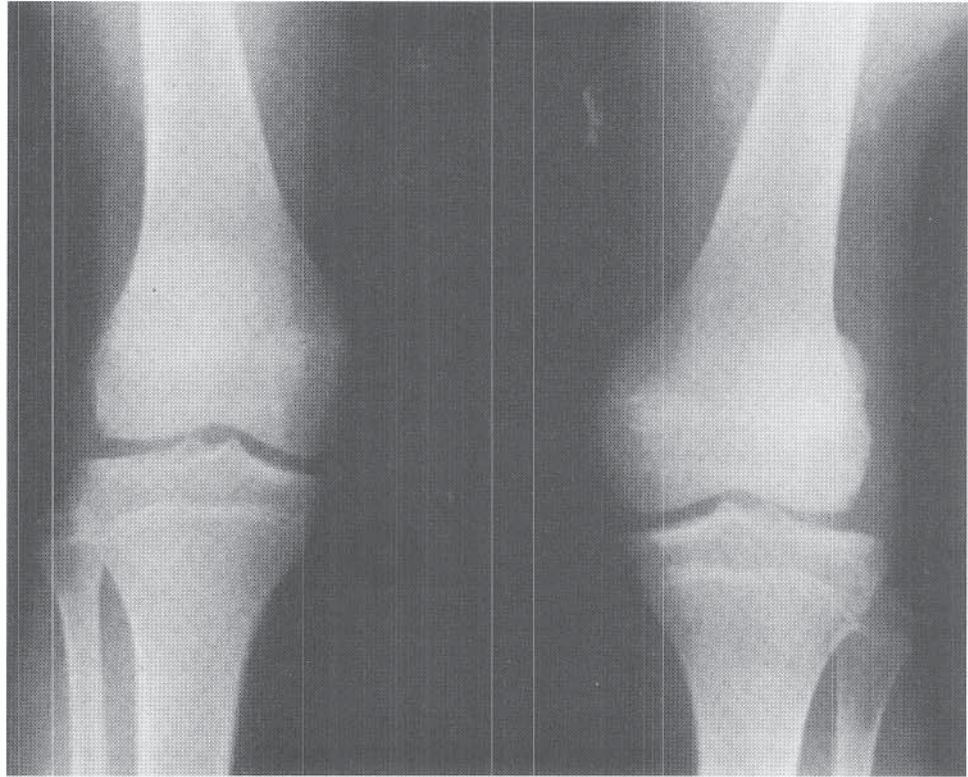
AP radiographs of both knees in a child with recurrent dislocation of the left patella, which is located in an abnormally lateral position.
